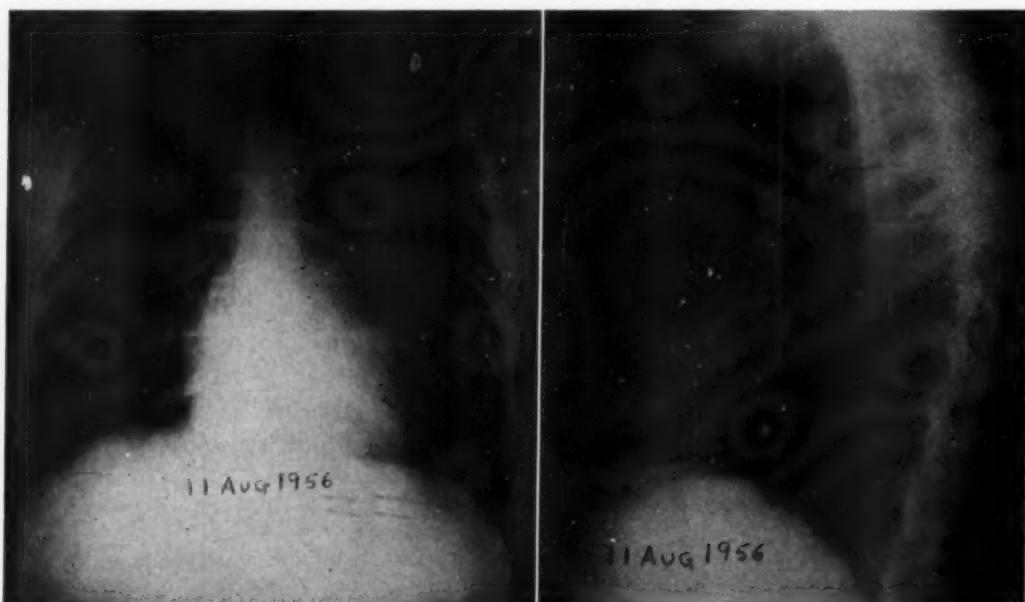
Roentgenograms of Aug. 11, 1956. *Left:* Postero-anterior view.
